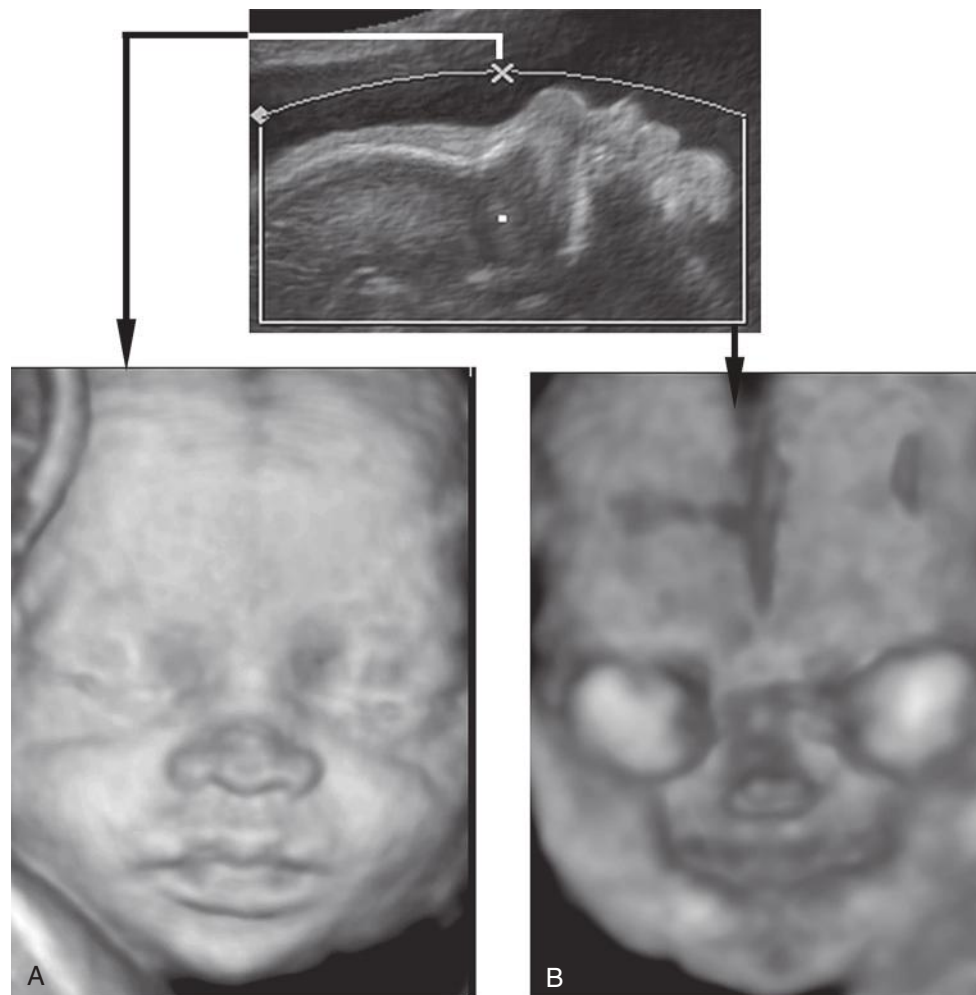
Three-dimensional ultrasound images showing anterior surface rendering (A) and reverse view skeletal rendering (B) of the fetal face. The same ultrasound volume is used, and the rendering displays are changed. The reverse view provides an image of the anterior palate and nasal fossa.
